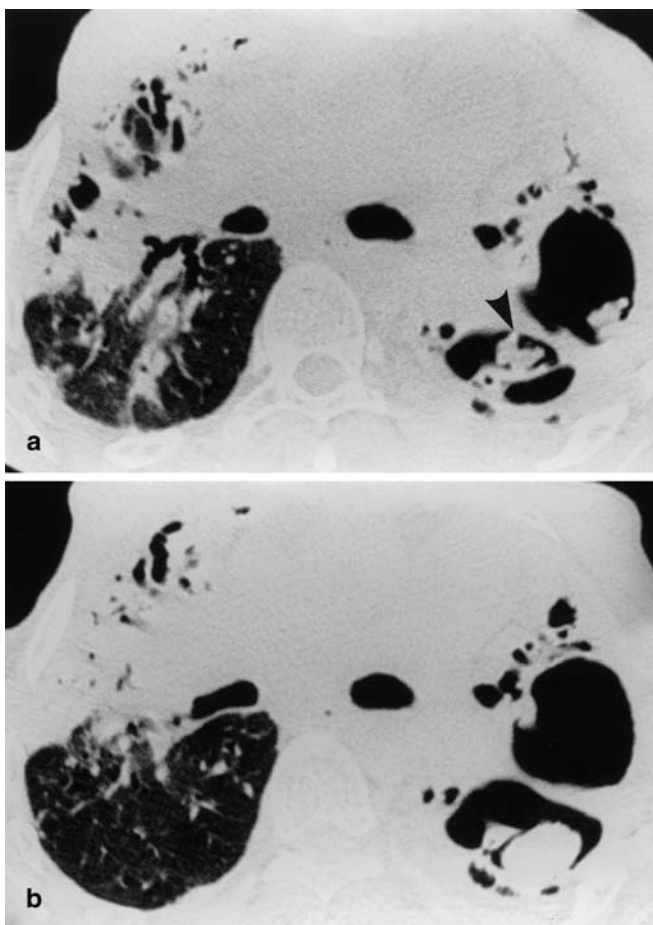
The development of aspergilloma shown on CT. a Left apical cavity with pleural thickening and fronds and finger-like projections arising from the cavity wall (*arrowhead*) in a patient with severe fibro-cavitary disease. b Fourteen months later, the fronds have broken away from the wall and formed a mature fungus ball
